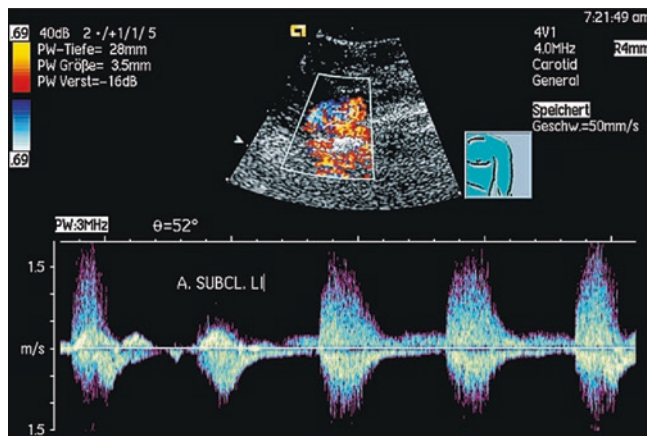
Stenosis of the subclavian artery. In spite of high pulse repetition frequency (maximum 69 cm/s), there is markedly faster flow within the vessel, which is imaged by the bright color pixels in the vessel. Furthermore, the vessel itself is poorly delineated; color pixels are also seen outside of it. This is also known as a vibration artifact and is caused by tissue vibration secondary to stenosis and due to concomitant pulsations that cannot be reliably distinguished from the vessel in terms of space. Spectral Doppler shows flow maxima of about 1.5 m/s and retrograde flow (below the null line), as well as pathological, non-triphasic flow in this extremity artery
